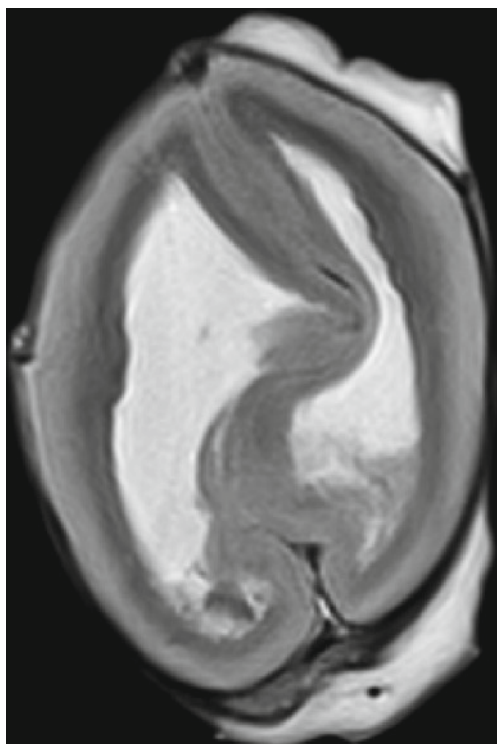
Axial MR image of a 24-week gestation fetus with severe ventriculomegaly. The ventricles have “collapsed” at death, hence the folded appearance of the parenchyma. The MR image will underestimate the true extent of the antenatally diagnosed ventriculomegaly, but allows it to be visualized and shows the surrounding parenchyma clearly
